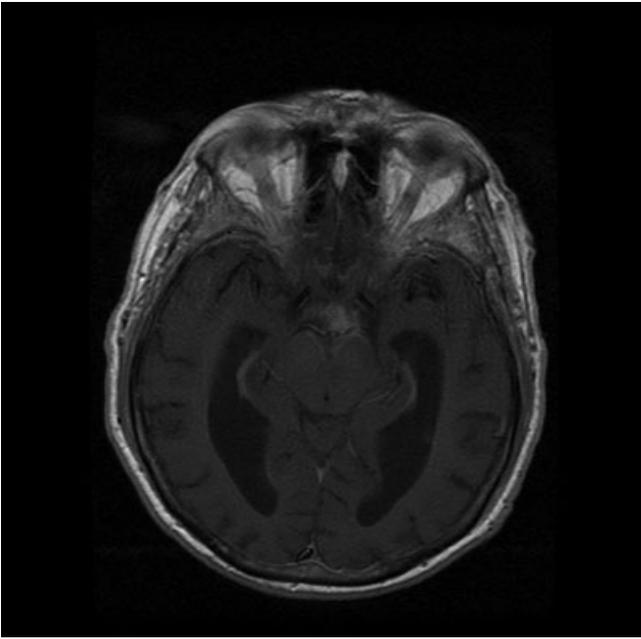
T1-weighted magnetic resonance imaging at diagnosis, showing supratentorial leptomeningeal enhancement.
